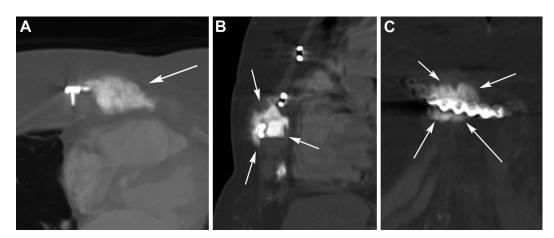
(A-C): (A) Axial, (B) coronal, and (C) sagittal CT images showing a recurrent sclerotic, osteoid matrix containing mass (arrows), which extends anterior through the Stryker plate hardware.
